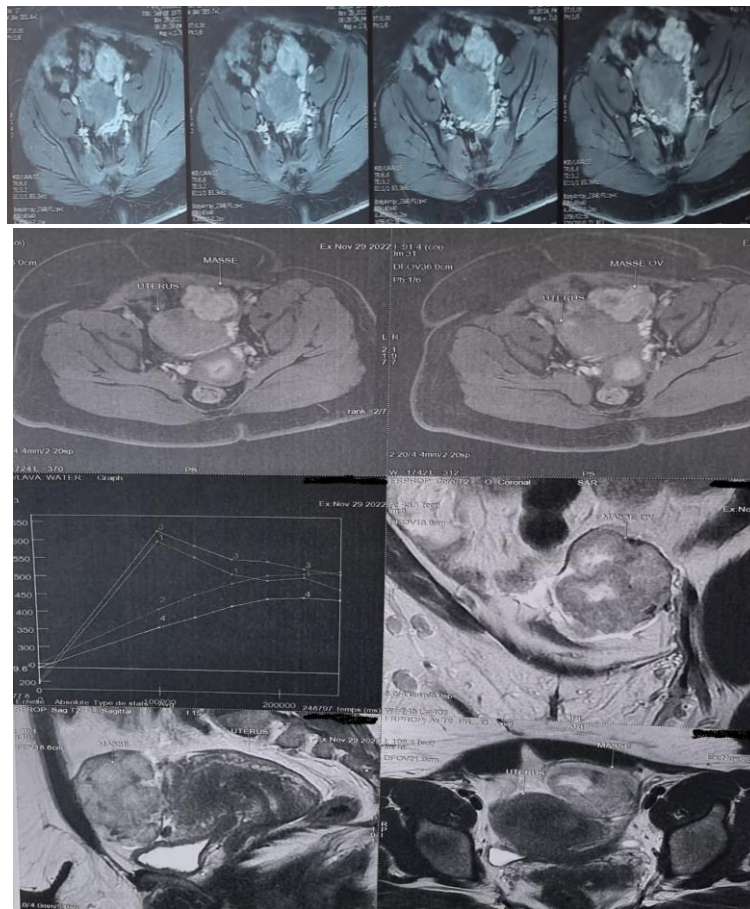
Pelvic MRI showing a roughly oval, polylobed left ovarian mass classified ORADS 5, measuring 53x65x87 mm
